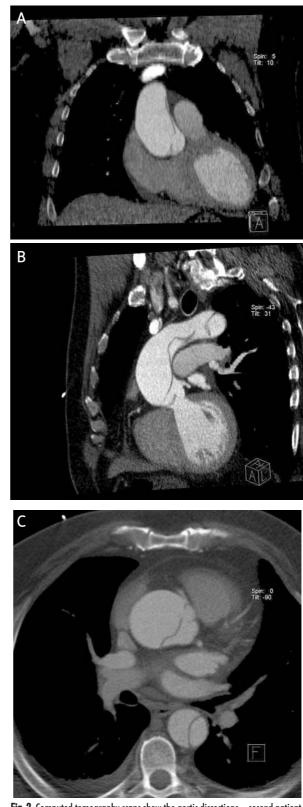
Computed tomography scans show the aortic dissections – second patient. See text for details
